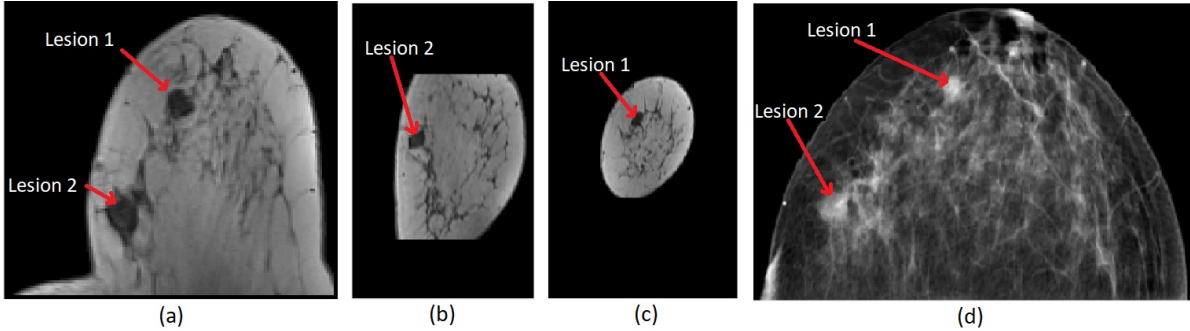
Sample case with visible lesions: (a) Lesions in an MRI slice (Transversal view); (b,c) Lesions in MRI slices (Sagittal view); (d) Same lesions depicted by mammography
